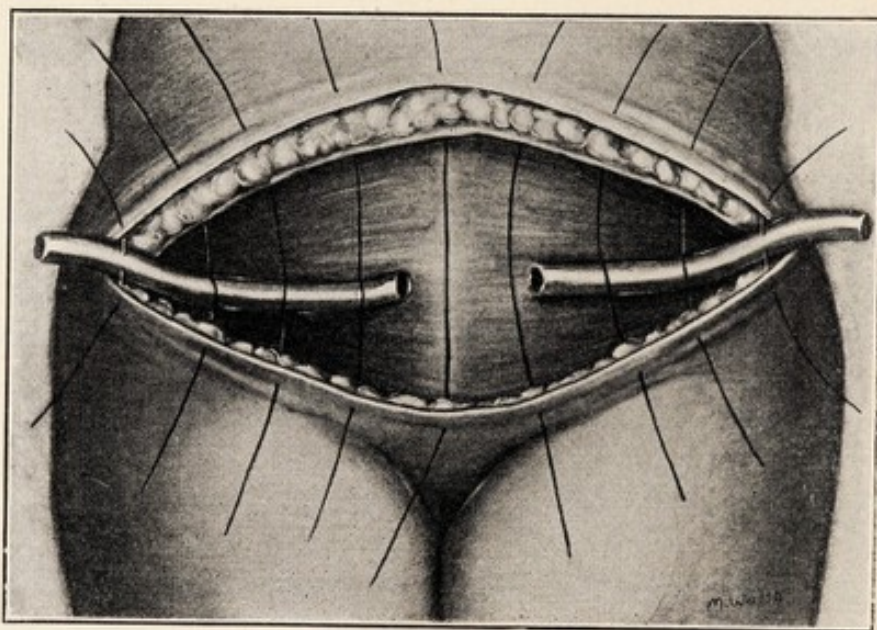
EXCISION OF X-RAY ULCER SEEN IN FIG. 170 WITH THE LIPECTOMY METHOD.
